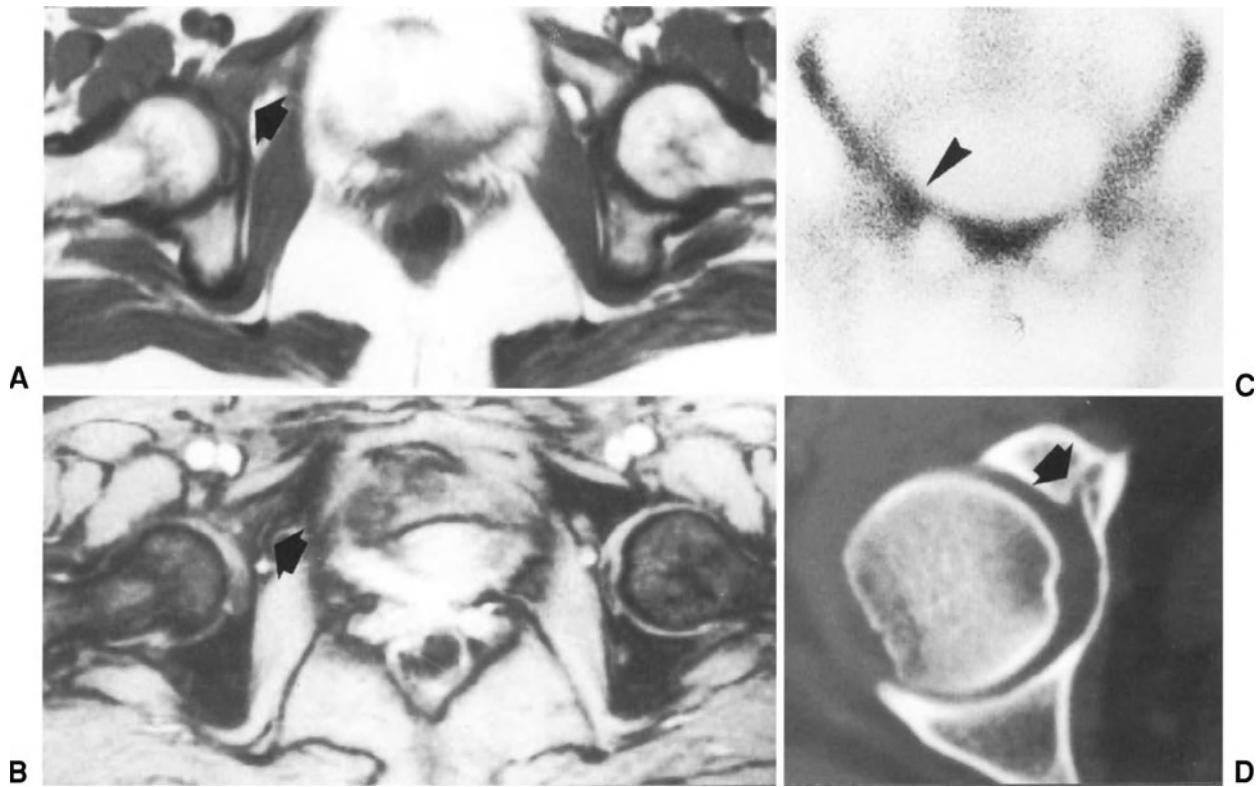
This 44-year-old female fell down the stairs and sustained trauma to the lumbar region and right buttock. After a few days, plain radiographs of the lumbar spine were obtained due to persistence of pain in the lower lumbar region, as well as in the right buttock and groin. Since the radiographs were normal, disc herniation was suspected and the patient was referred to a neurosurgeon, who requested CT scan of the lumbar spine, which showed no abnormalities. Sixteen days after the trauma, the patient was examined by another neurosurgeon, who requested MRI studies of the lumbar spine; since even the latter were normal, bed rest and anti-inflammatory therapy were prescribed. After 1 week of bed rest, the patient still complained of pain in the buttock and groin, particularly in the upright position and on walking. When examined by an orthopaedic surgeon, 26 days after the trauma, the patient presented slight limping due to groin pain, radiating to the upper portion of the anterior aspect of the right thigh. Neurologic examination was normal. Hip rotations and flexion were limited and painful. Plain radiographs of the hip were normal. MRI of the hip – (A) and (B) – showed abnormal signal intensity in the region of the right acetabulum on T1- and T2-weighted images (arrows). Bone scan (C) showed increased uptake in the right acetabulum (arrowhead), and the subsequent CT (D) revealed a fracture of the acetabulum (arrow). In this case, scrupulous physical examination should have led the examiner to suspect a pathologic condition of the hip, soon after the trauma.
